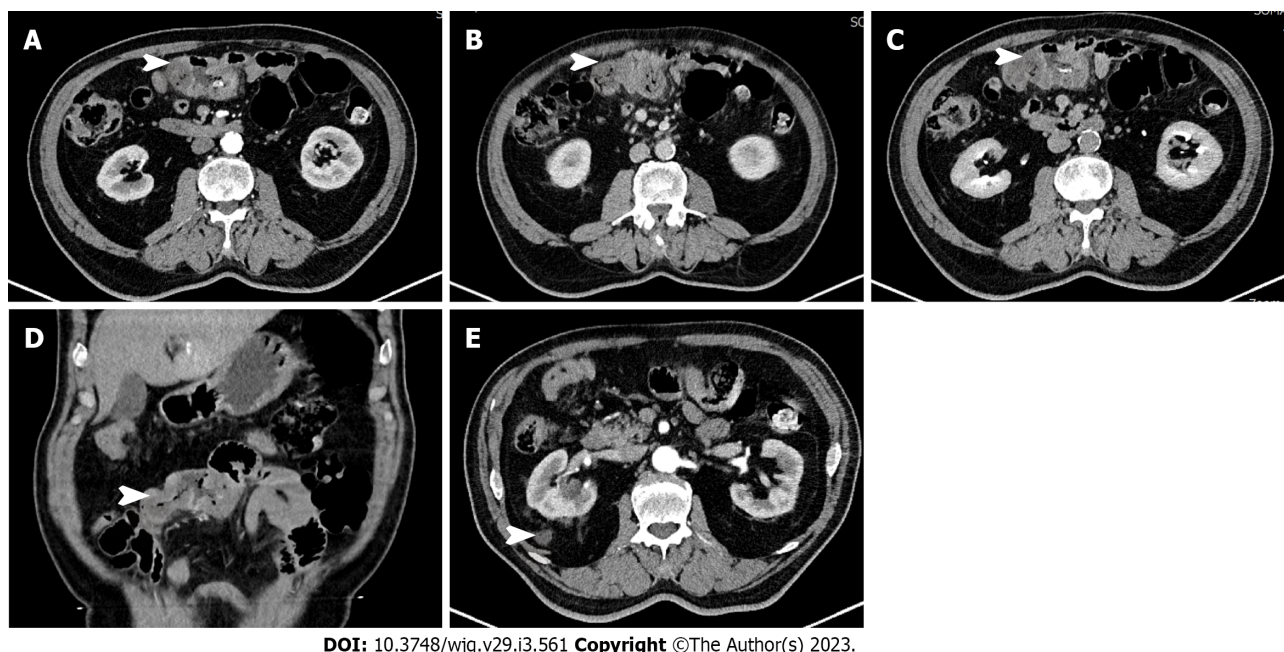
Computed tomography showed segmental thickening of the small intestine (white arrow), with lesion enhancement in the arterial phase. A: Arterial phase; B: Venous phase; C: Balanced phase; D: Coronal plane; E: Adrenal masses.
